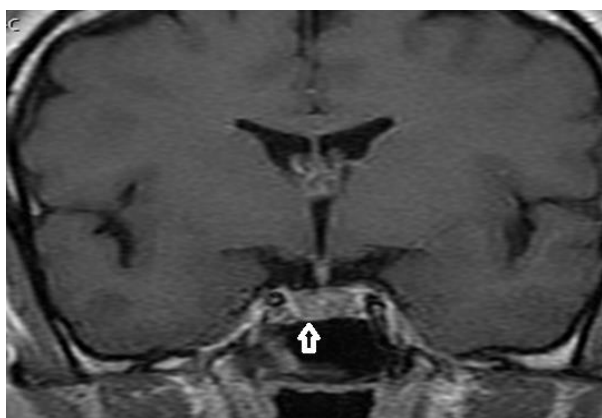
T1WI post contrast coronal MRI image at the level of the pituitary showing subtle focal enlargement of the pituitary gland on the right side with inferior bulge (white arrow) of the floor of the pituitary fossa.
